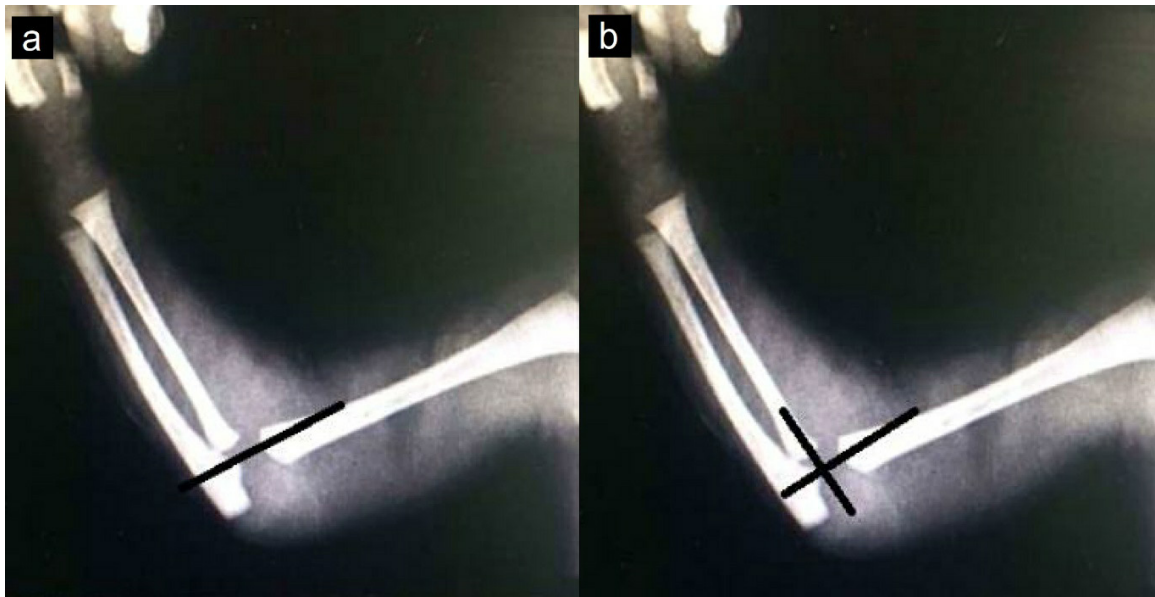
Radiograph in profile of distal humerus epiphyseal fracture. Image shows absence of mineralization of the capitulum's ossification center
